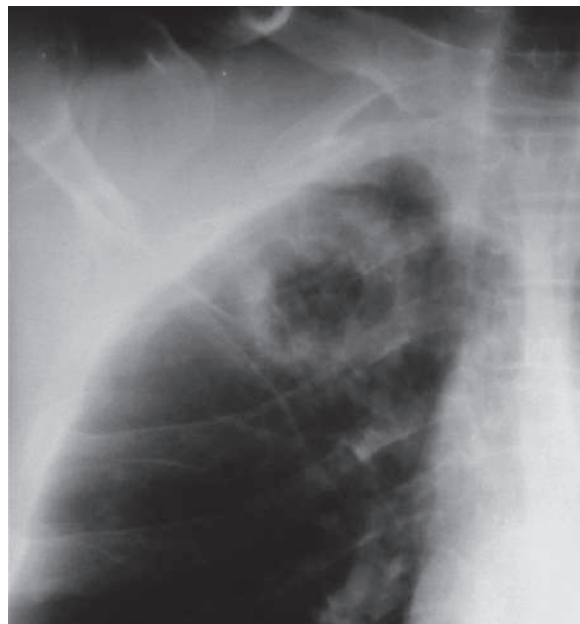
Posteroanterior plain chest radiograph shows right apical TB cavity
